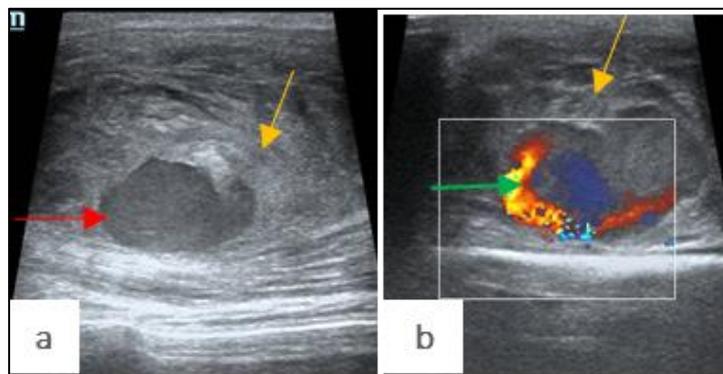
Cross-sectional ultrasound in B mode (a) and color Doppler mode (b): pseudoaneurysm (red arrow) of the left ulnar artery in the form of a hypoechoic lesion in contact with the ulnar artery, well limited and with turbulence, producing a Ying Yang sing in color Doppler (green arrow) with the presence of an endoluminal thrombus (yellow arrow)
